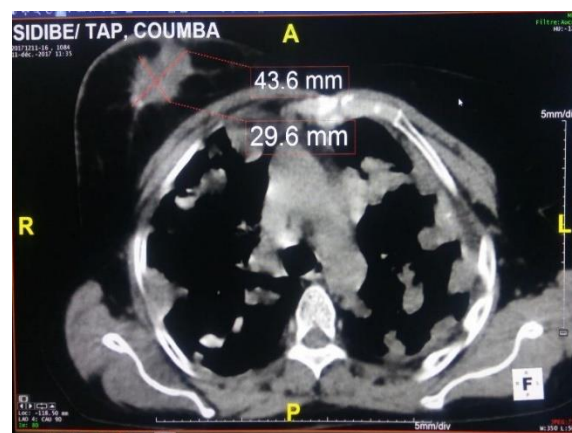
Thoracic CT scan in axial section and mediastinal window (b): after injection of contrast product, highlights balloon releases of a right breast mass in a 45-year-old woman
